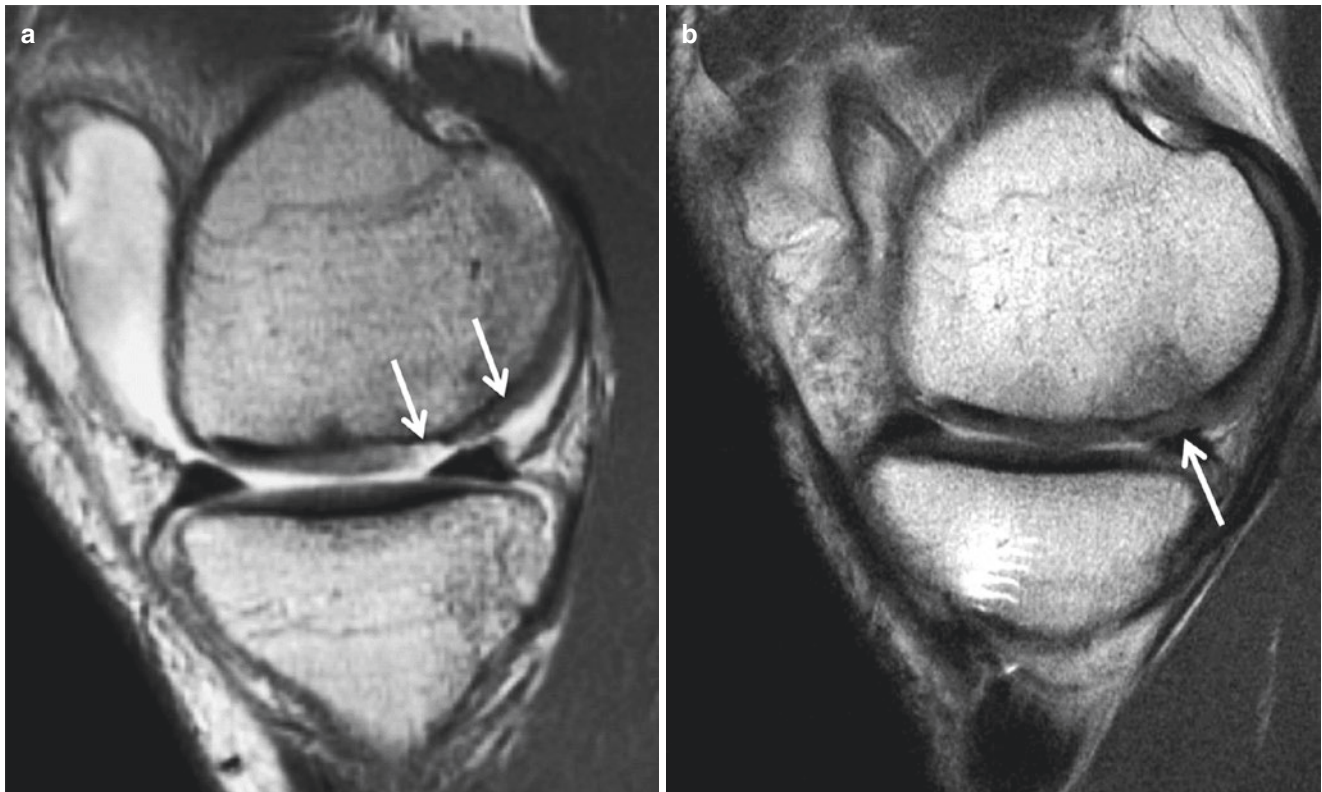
A 39-year-old man with medial femoral condyle cartilage lesion managed by microfracture. (a) Initial sagittal T2-weighted image shows areas of partial- and full-thickness cartilage loss (*arrows*). (b)
